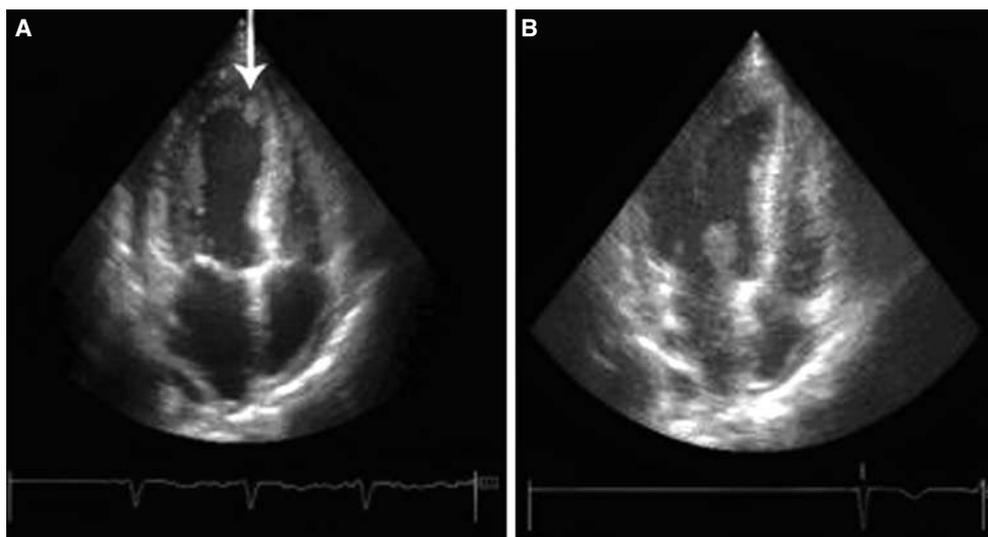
(A) Apical four-chamber view showing a mass, 1x1 cm in size, compatible with thrombus (arrow) in the left ventricular apex. (B) Echocardiographic image obtained five days after initiation of heparin therapy shows resolution of the thrombus.
